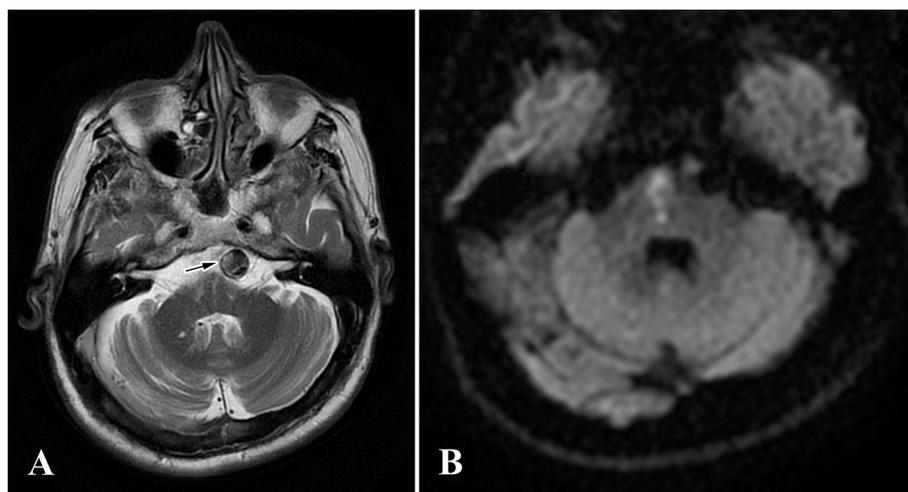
A dissection and a pseudoaneurysm (arrow) of the basilar artery on a T2-weighted axial MRI scan compressing the pons (A), and a small paramedian pontine ischemic lesions on a DWI axial image (B).
